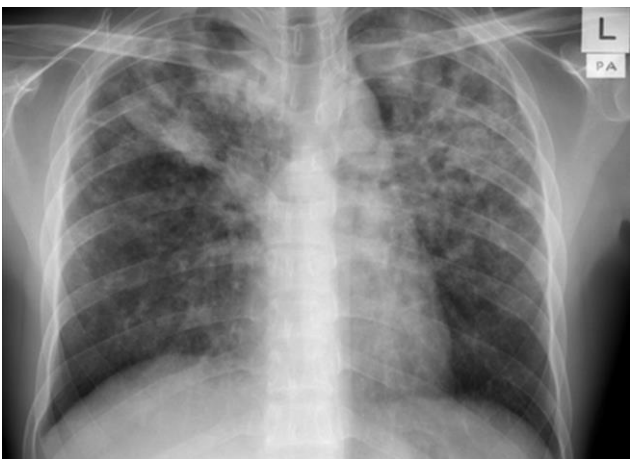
Anterior and posterior view of chest xray showing bilateral nodular and interstitial opacities more at upper and middle zone consistent with pulmonary tuberculosis changes.
